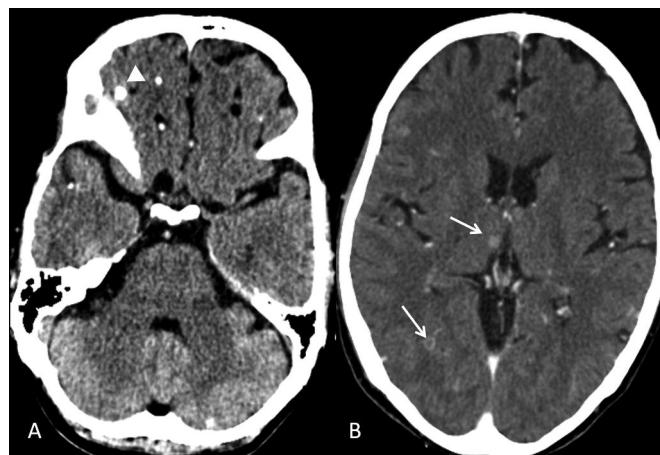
A. Plain CT shows few calcified subcentimetre sized lesions (arrowhead) in the bi-frontal and right temporal lobe. B. Contrast enhanced CT shows few ring enhancing lesions (arrow).
